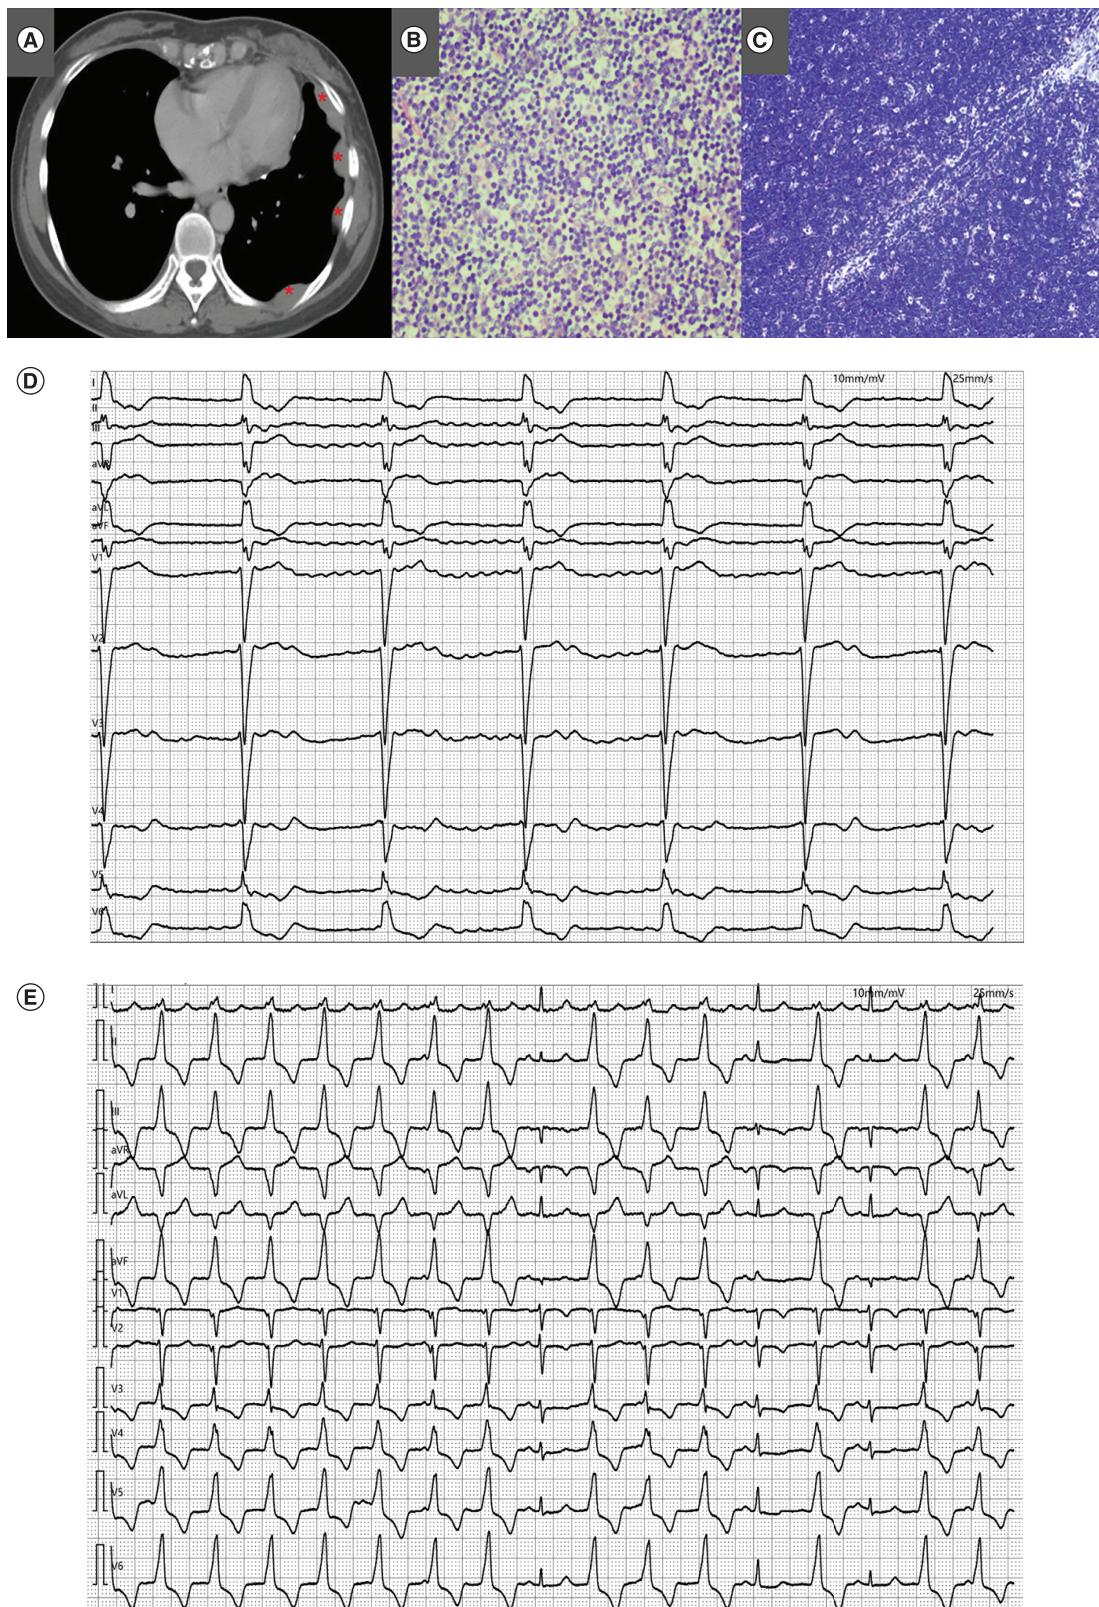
Characteristic of patient 2. (A) Multiple pleural and diaphragmatic metastases. (B) Pathological diagnosis of case 2 was WHO type B1 thymoma. (C) Negative PD-L1 expression. (D & E) Echocardiogram showed third-degree atrioventricular block and ventricular arrhythmia.
